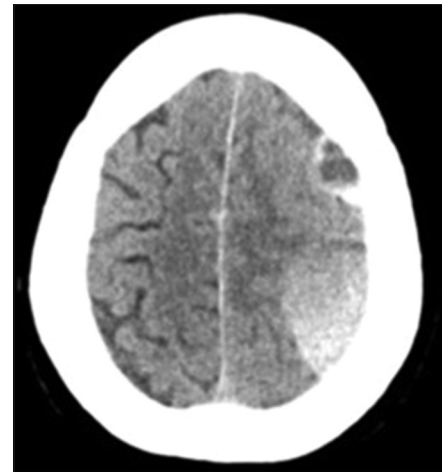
Computed tomography of the head showed an acute left frontoparietal subdural hematoma and hematoma at left parietal convexity with 5 mm midline shift. This occurred in the setting of anticoagulation with enoxaparin bridged to warfarin for the aortic valve thrombus
